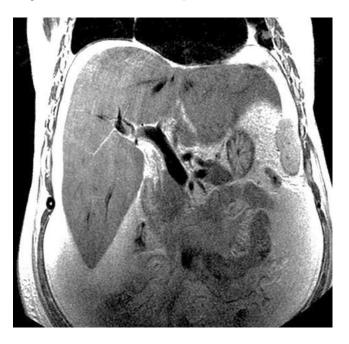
Thinning of the suprahepatic veins and portal vein of preserved caliber (MRI). Source: Radiology Service, Víctor Lazarte Echegaray Hospital.
